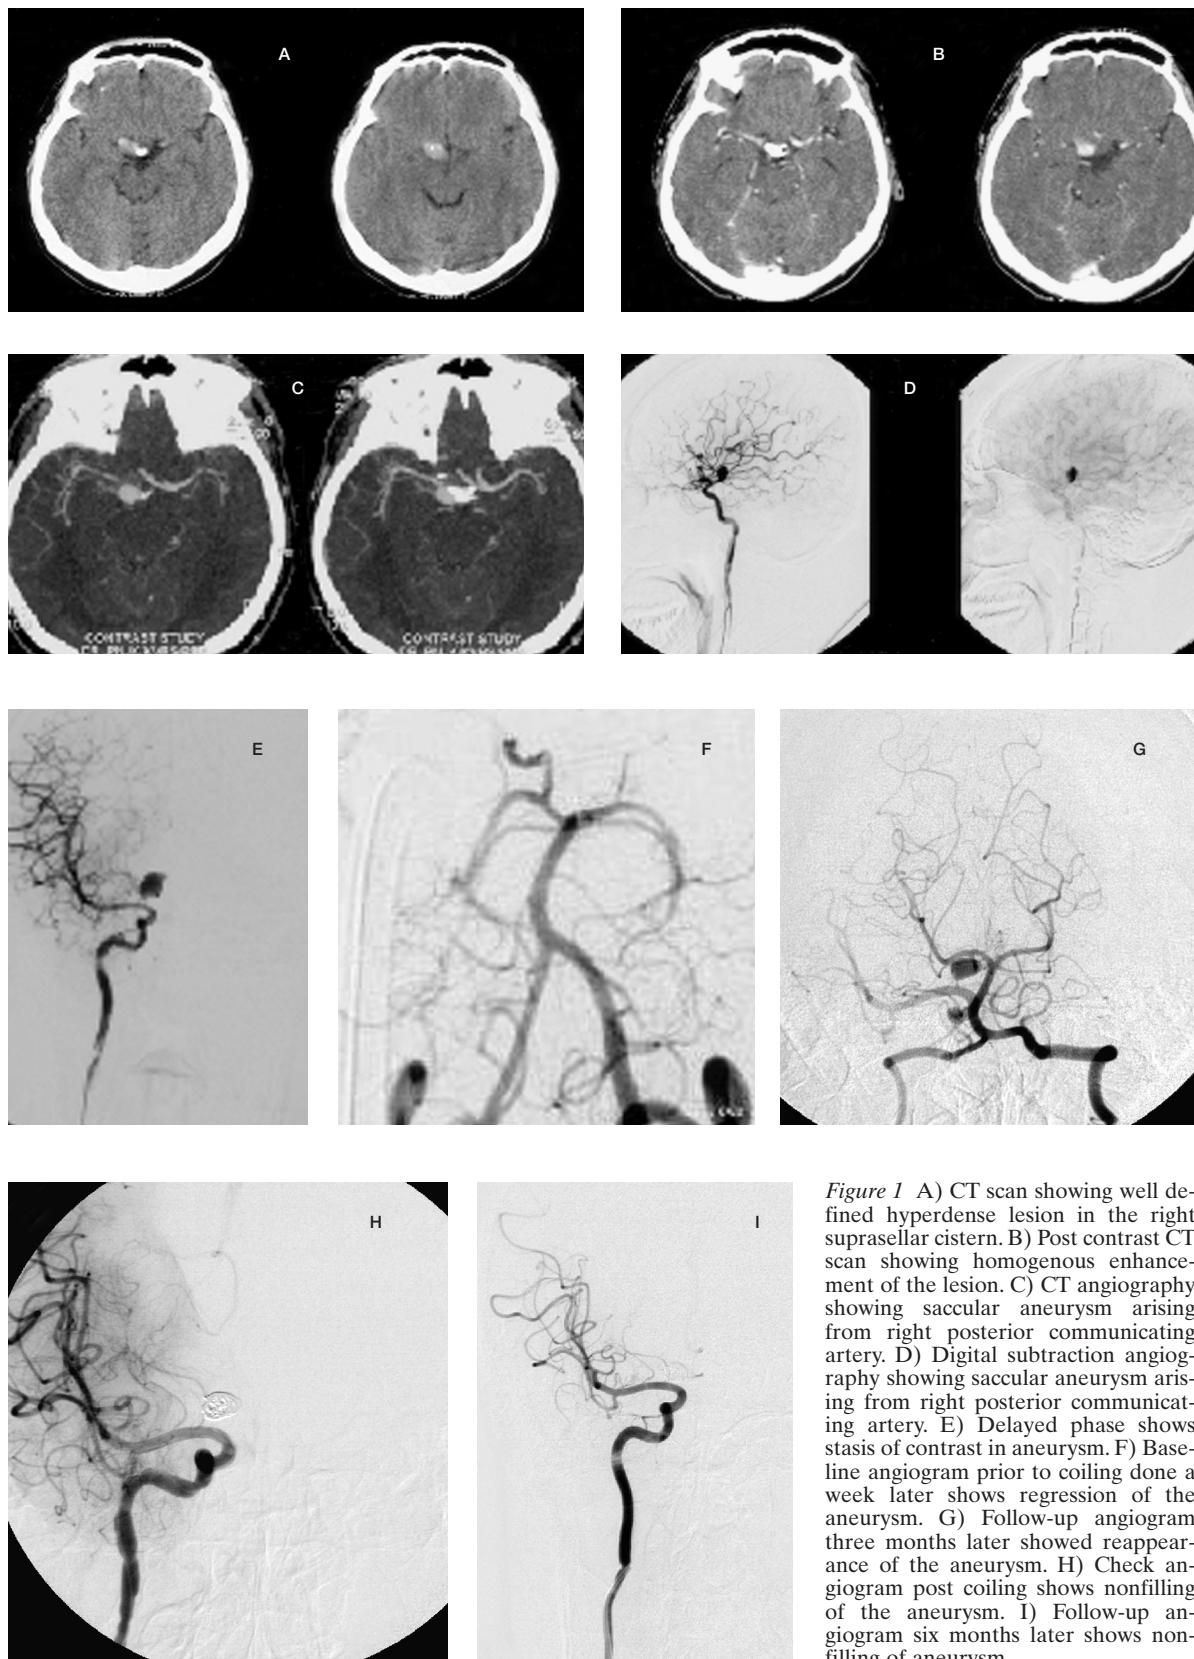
A) CT scan showing well defined hyperdense lesion in the right suprasellar cistern. B) Post contrast CT scan showing homogenous enhancement of the lesion. C) CT angiography showing saccular aneurysm arising from right posterior communicating artery. D) Digital subtraction angiography showing saccular aneurysm arising from right posterior communicating artery. E) Delayed phase shows stasis of contrast in aneurysm. F) Baseline angiogram prior to coiling done a week later shows regression of the aneurysm. G) Follow-up angiogram three months later showed reappearance of the aneurysm. H) Check angiogram post coiling shows nonfilling of the aneurysm. I) Follow-up angiogram six months later shows non-filling of aneurysm.
